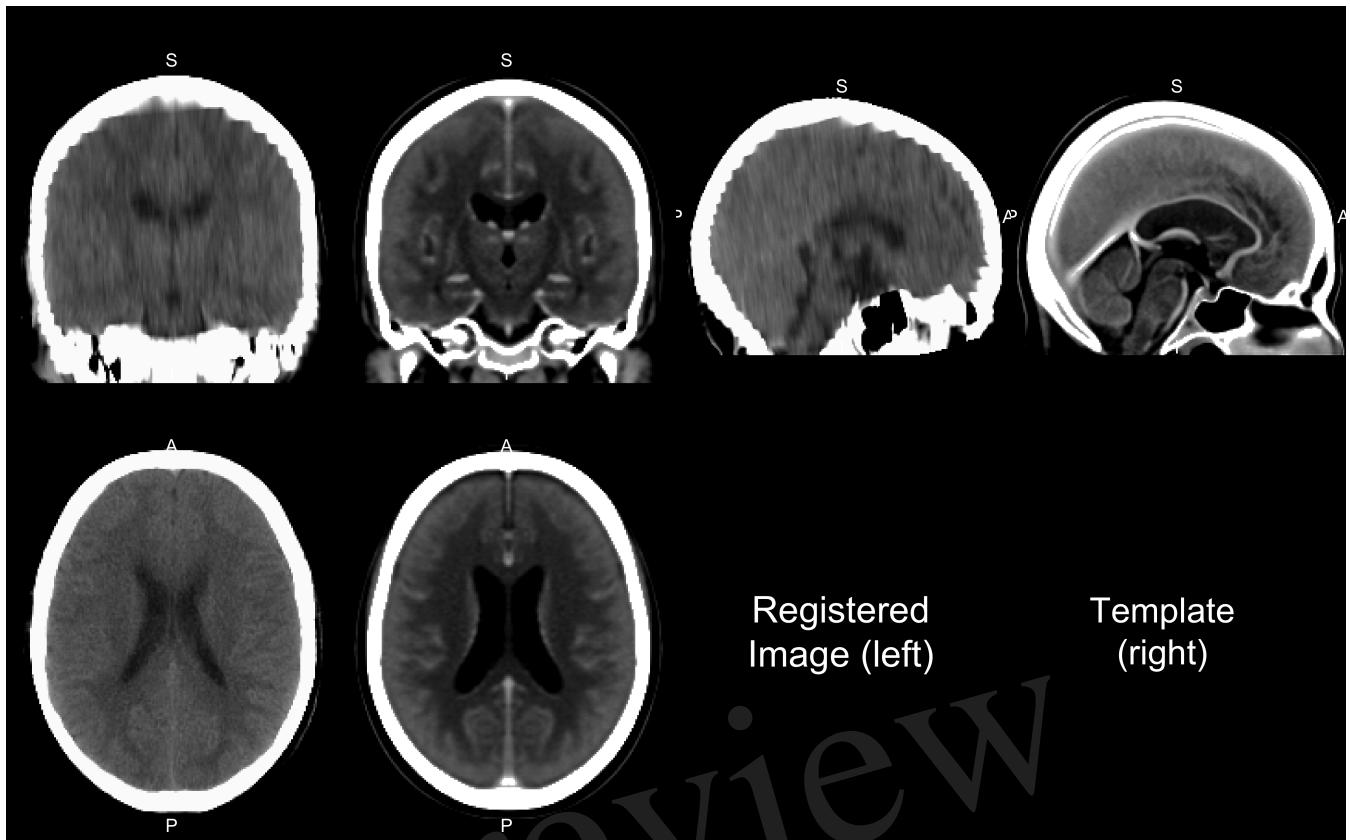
Image Registration Result. Here we use the same scan that we performed brain extraction before, and register it to a CT template (Rorden, 2012). We registered the image using symmetric normalization (SyN), a non-linear registration done after affine registration. We see areas of the image that align generally well, but may not be perfect.
